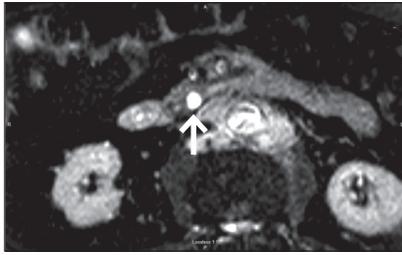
Axial fat-saturated T2-weighted magnetic resonance image. The white arrow indicates a 1.2-cm simple cyst in the region of the uncinate process.
